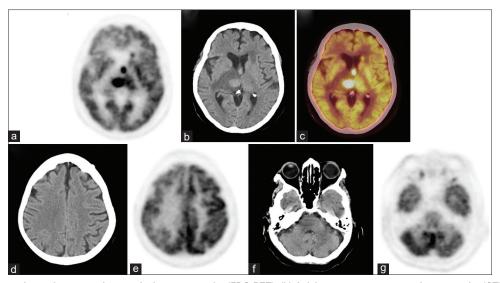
(a) F-18 fluorodeoxyglucose positron emission tomography (FDG PET), (b) Axial noncontrast computed tomography (CT) and (c) fused F-18 FDG PET-CT showing intense FDG uptake in an isodense lesion in the interventricular region, abutting anterior horn of left lateral ventricle. Another FDG avid isodense lesion is noted in the right thalamus and associated with disproportionate perilesional edema, with maximum standardized uptake value of 26.7. (d and e) Axial noncontrast CT and F-18 FDG PET showing diffuse decreased metabolism in the right cerebral hemisphere. (f and g) Axial noncontrast CT and F-18 FDG PET showing diffuse decreased metabolism in the left cerebellar hemisphere—indicative of "crossed cerebellar diaschisis"
